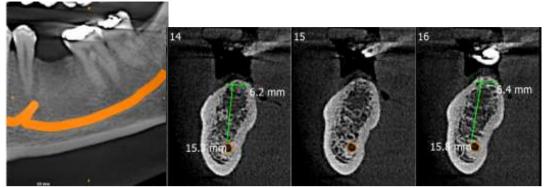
CBCT of the concerned area
